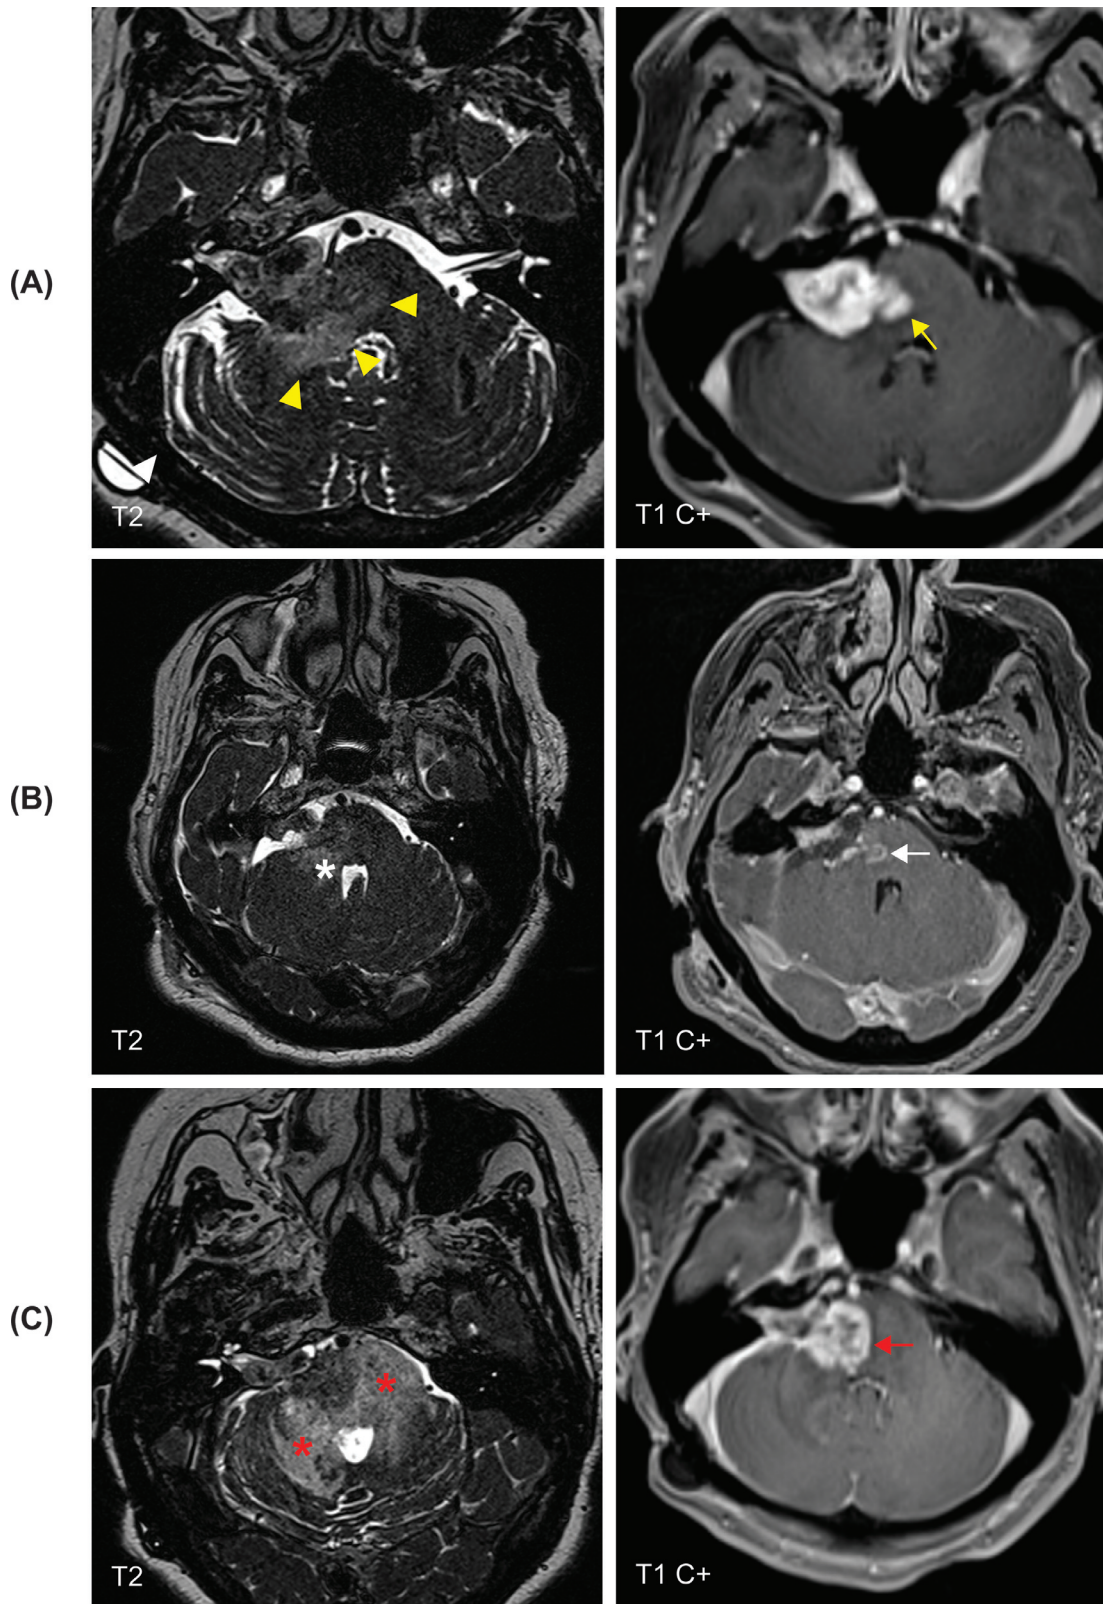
(A) MRI 6 years post-SRS showed changes in tumor morphology with increasing vasogenic edema (yellow arrowheads) and a new area of enhancement extending from the medial aspect of the tumor to the brainstem (yellow arrow). (B) Imaging post right suboccipital craniectomy confirmed the presence of a residual lesion with persistent enhancement in the right hemi pons (white arrow) and abnormal signal in the brachium pontis (white asterisk). (C) Following the completion of adjuvant radiation, imaging showed an increase in residual lesion size (red arrow) and worsening signal abnormality in the adjacent brainstem and brachium pontis (red asterisks) possibly reflecting treatment-related changes or disease progression.
